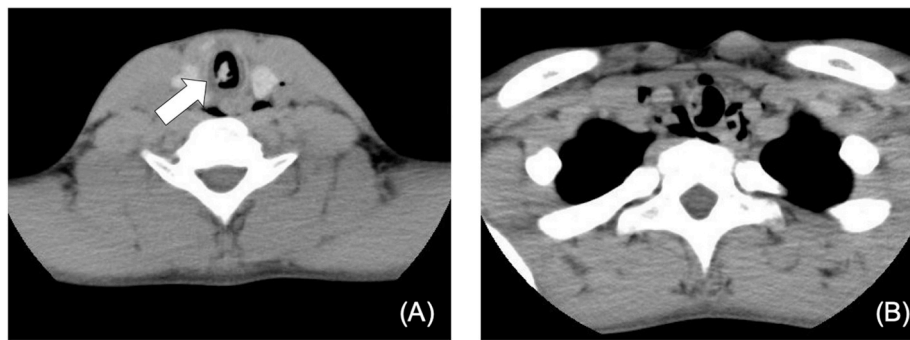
Contrast-enhanced computed tomography of the neck. (A) Axial CT scan showing the foreign body in the trachea (white arrow). (B) Axial CT scan showing emphysema around the trachea at the level of clavicle.
